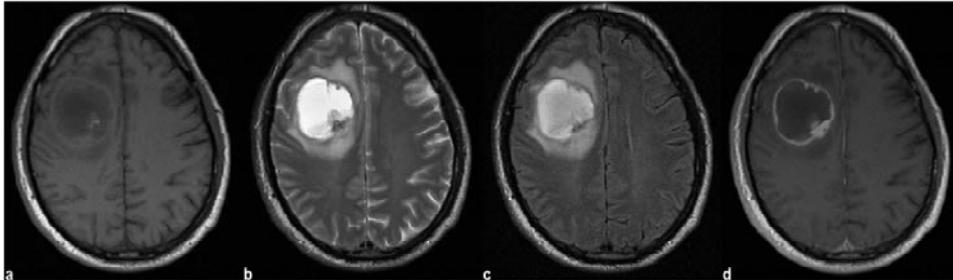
MR images of a glioblastoma: (a) T1-weighted (b) T2-weighted (c) T2-weighted FLAIR (d) and T1-weighted contrast enhanced [35]
